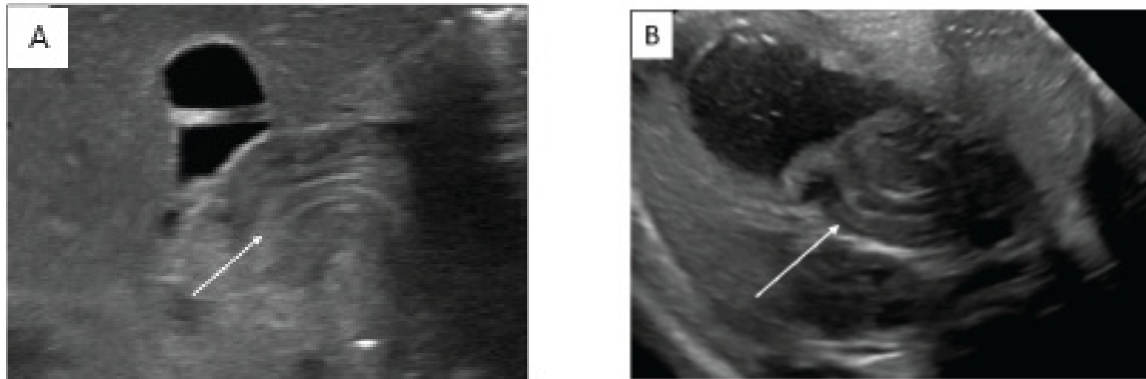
Abdominal Ultrasound. A, Abdominal ultrasound at 3 weeks of age shows a pyloric wall thickness of 4 mm, a pyloric channel length of 19 mm, and no passage with feeds. White arrow indicates the pylorus. B, Abdominal ultrasound at 11 weeks of age shows a pyloric wall thickness of 5 mm, a pyloric channel length of 19 mm, and no passage of feeds. White arrow indicates the pylorus
